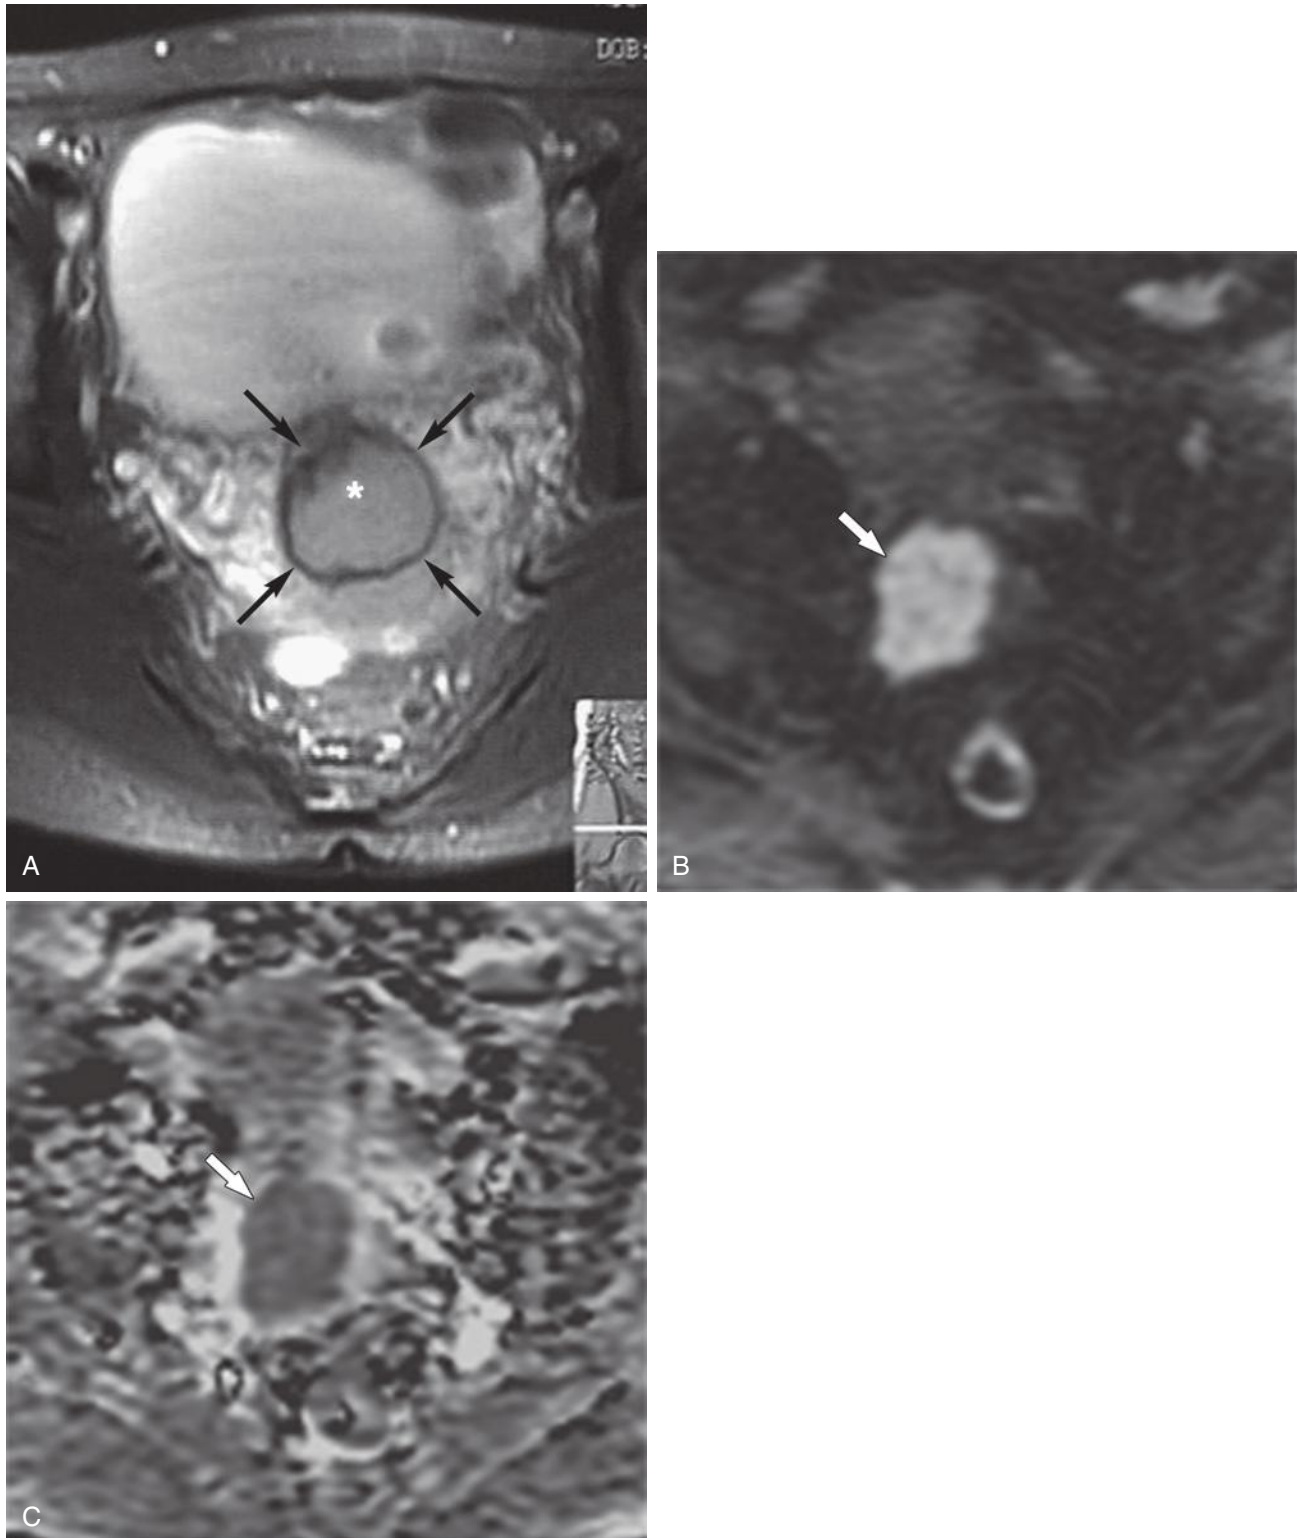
Stage IB cervical cancer. Axial T2-weighted (A), diffusion-weighted (B), and absolute diffusion coefficient or ADC (C) images. T2-weighted image (A) shows a mass (*asterisk*) of intermediate signal intensity confined to the cervix, with a preserved peripheral T2-weighted hypointense cervical stromal ring (*arrows* in A). Increased signal intensity (*arrow*) on diffusion-weighted image (B) and hypointense signal intensity (*arrow*) on the ADC image (C) within the mass indicate restricted diffusion.
